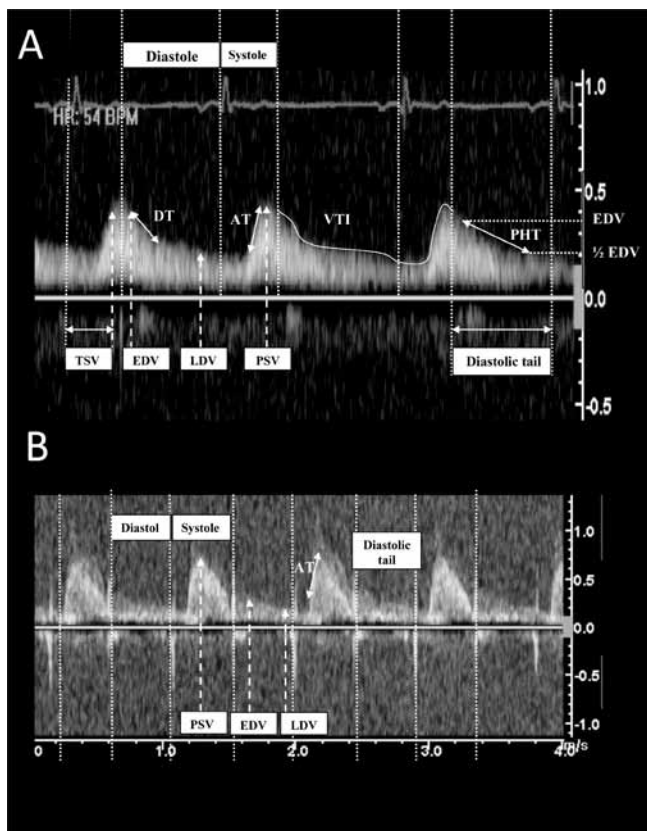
Pulse wave Doppler echocardiography of abdominal aorta: A; before stenting, B; after stenting. AT; systolic acceleration time: is measured from the onset of the systolic upstroke to the systolic peak. DT; deceleration time: is measured from peak E velocity to the point where the slope of the slowing flow would intercept the baseline. EDV; early diastolic velocity: maximum diastolic velocity on early diastole. LDV; late diastolic velocity: maximum diastolic velocity on late diastole. PHT; pressure half time (of diastole): is the time interval for the peak diastolic pressure gradient to be reduced by one half. PSV; peak systolic velocity: maximum systolic velocity. TSV; time to peak systolic velocity: time beginning from onset of QRS complex to peak systolic velocity. VTI; velocity time integral: the area under curve, shown in both systole and diastole
